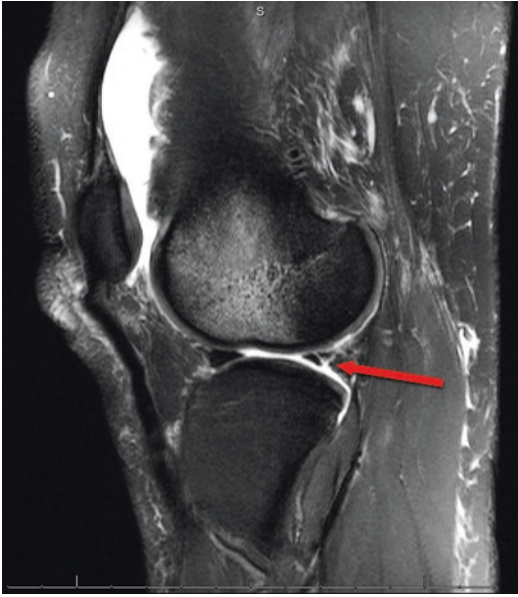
Sagittal view of a knee T2 weighted MRI image depicts a concomitant posterior horn lateral meniscus tear (*red arrow*) in a pediatric patient with a combined ACL/MCL injury. Published with kind permission of © Theodore J. Ganley 2017. All Rights Reserved
